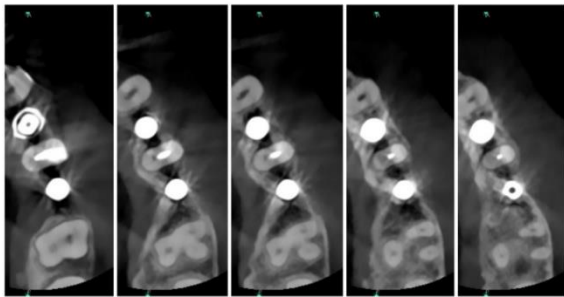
Consecutive CBCT slices – axial view from left to right coronal to apical.
